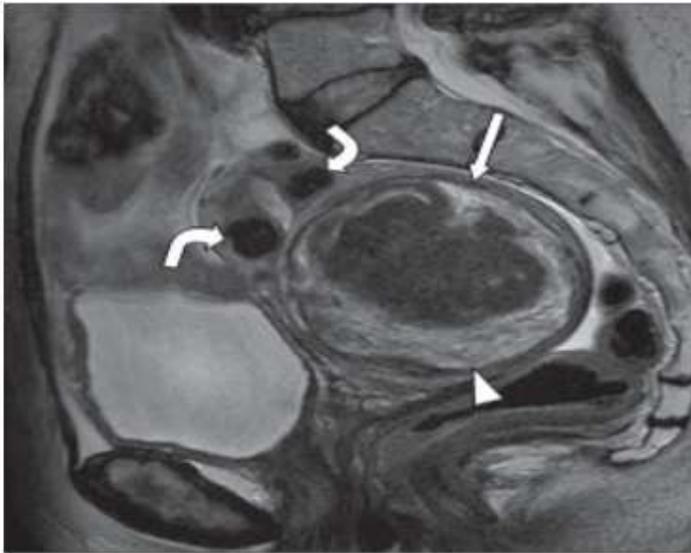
Image no: 3 Sagittal T2W MRI image shows a 7-cm intramural fibroid
